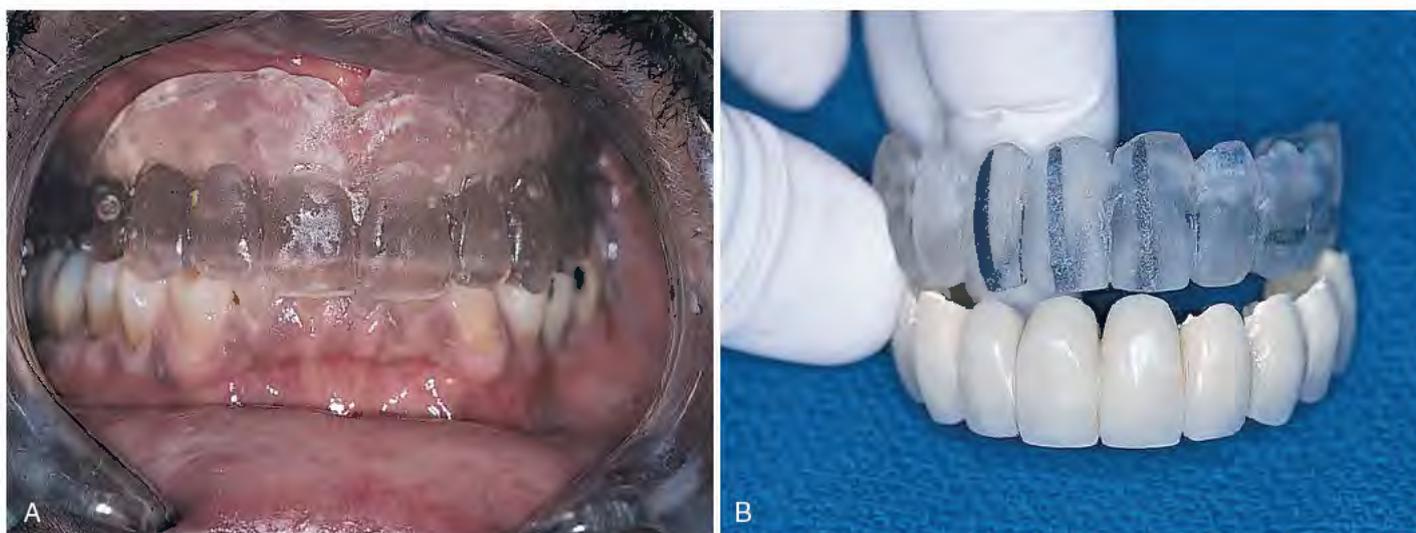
A, The template is tried in the mouth to ensure comfort and proper occlusion. Final adjustments often are required at this step. B, A temporary fixed prosthesis may be duplicated in a Lang duplicator to form a surgical template and CT scan template.
